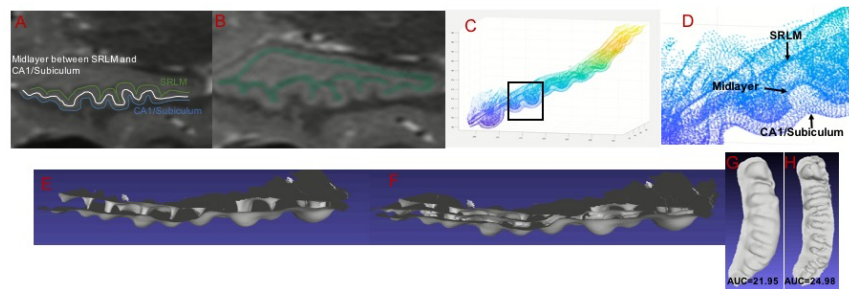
Demonstration of our method to quantify dentation on the midlayer between SRLM and inferior surface of the CA1/subiculum. (A) Identification of SRLM, inferior surface of the CA1/subiculum and Midlayer on high resolution T2 MRI data shown by green, blue and white curved lines, (B) manual segmentation of SRLM on high resolution T2 MRI data, (C) display of SRLM, inferior surface of the CA1/subiculum and midlayer as point cloud data with black box highlighting it, (D) zoomed in view of SRLM, inferior surface of the CA1/subiculum and midlayer shown by black arrows, (E) surface mesh of SRLM and inferior surface of the CA1/subiculum without midlayer, (F) surface mesh of SRLM, midlayer and inferior surface of the CA1/subiculum, (G) inferior surface of the CA1/subiculum showing dentation and its AUC value and (H) surface of midlayer showing prominent dentation than inferior surface of the CA1/subiculum and its AUC value.
